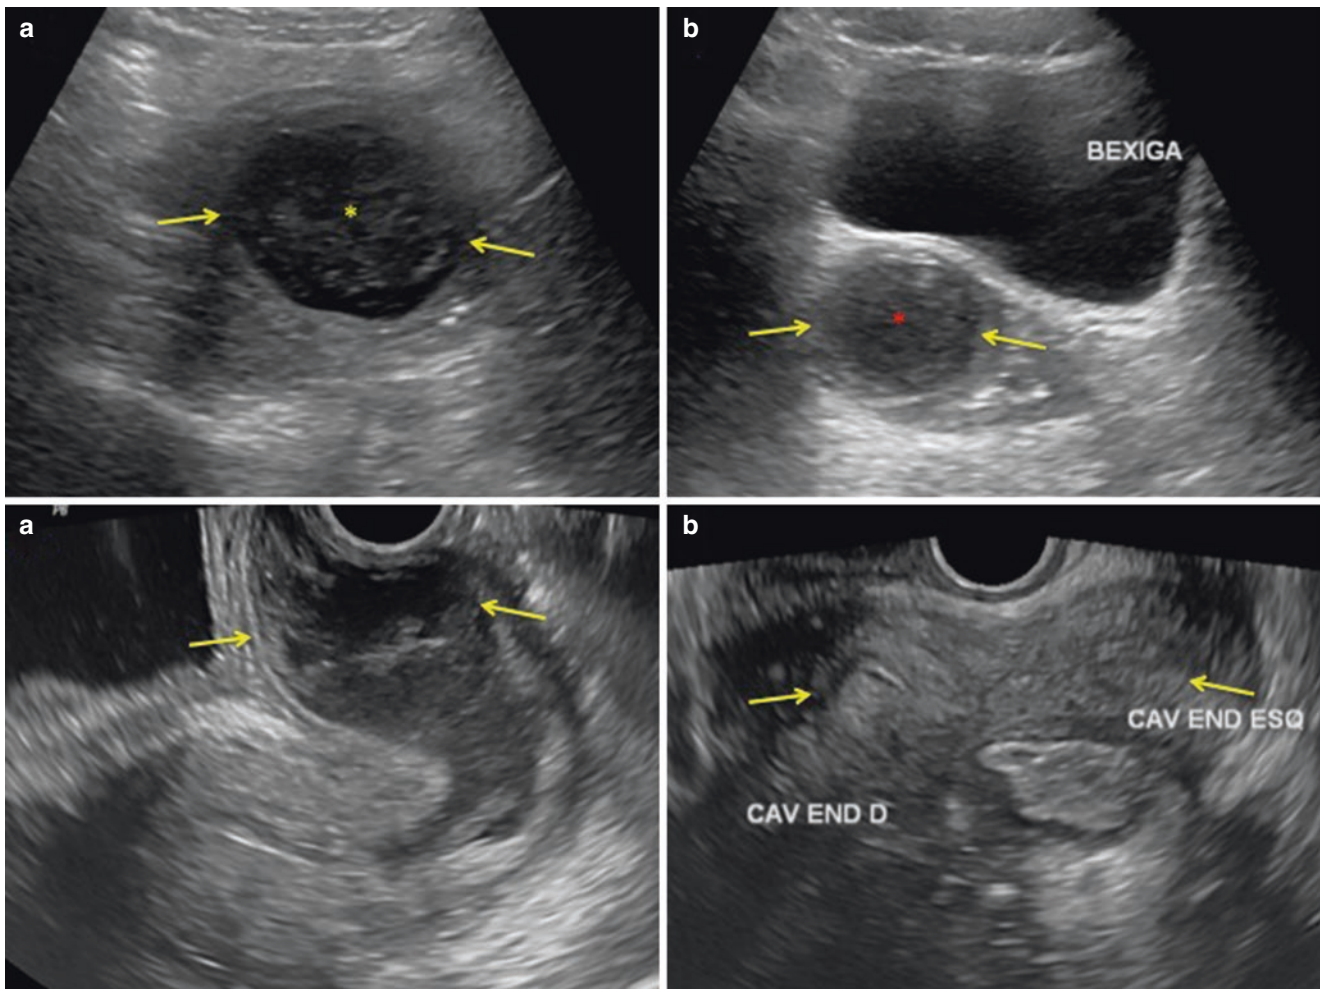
A 25-year-old patient with fever, abdominal pain and signs of peritonitis. Presented to the emergency room where suprapubic and trans-vaginal ultrasound exams were carried out initially. (a) Axial image of a circumscribed hypoechoic lesion of the mesogastric region (*yellow arrows*); the intralésional content is thick (*red asterisk*). (b) Suprapubic ultrasound revealing oval-shaped hypoechoic lesion
